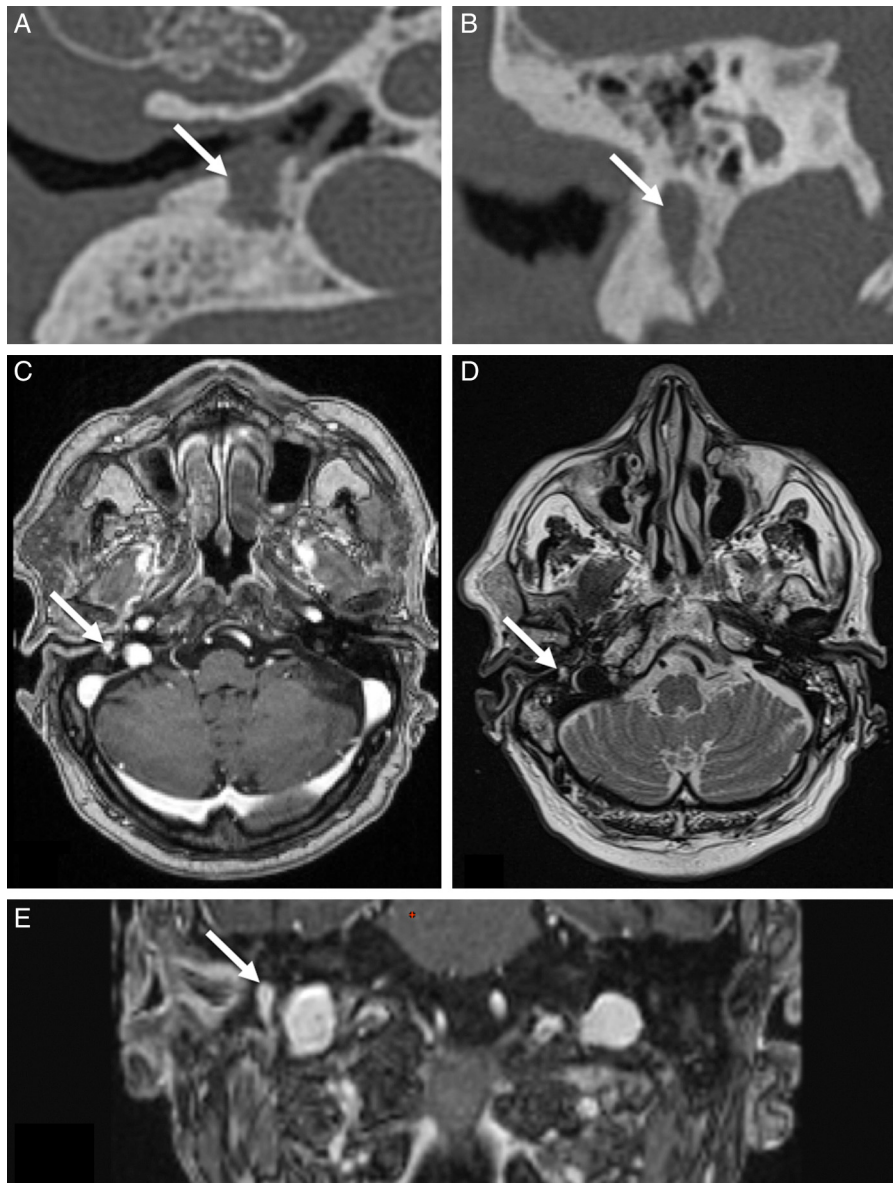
Radiological examination of chorda tympani schwannoma with associated MOE. (A) Axial CT scan demonstrating well-defined soft tissue lesion. (B) Reconstructed coronal CT image demonstrating above soft tissue lesion caused an osteolytic erosion of the mastoid along the vertical segment of the facial nerve. (C) T1 with gadolinium MRI image in axial projection: the chorda tympani tumor exhibits a homogenous hyper-enhancement. (D) The MRI axial T2-weighted image in axial projection shows the hyperintense schwannoma. (E) T1 with gadolinium MRI image in coronal projection: the chorda tympani tumor exhibits a homogenous hyper-enhancement. MOE, malignant otitis externa; CT, computed tomography; MRI, magnetic resonance imaging.
